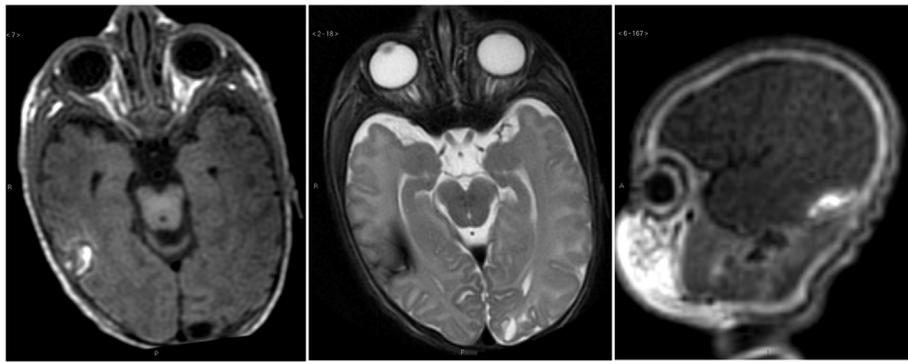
MRI at 1 month of life: T1- and T2-weighted axial images and sagittal T1-weighted image show a reduction of hemorrhagic right parietal and temporal lesions; T2 axial image shows subcortical cavitations in the parieto-occipital white matter, as cystic encephalomalacia.
